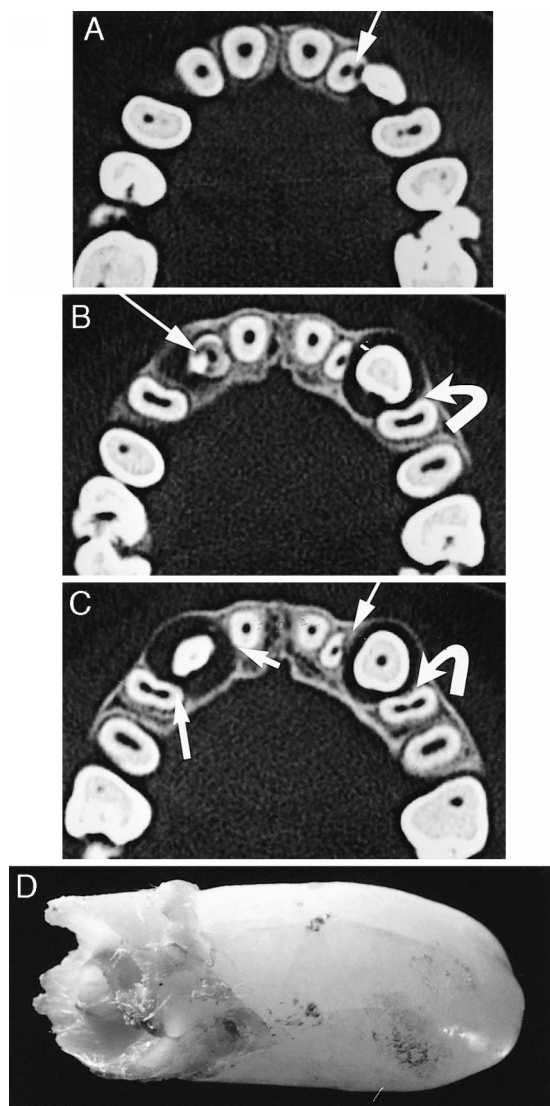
Findings in a 12-year-old boy. (A–C) Axial computed tomography (CT) scans obtained on the same occasion. No. 13 is erupting apically to No. 12. The dental follicle is symmetrically enlarged (C, arrows). The buccal cusp of No. 13 hits the root of No. 12 (B, arrow). There is extensive resorption of No. 12 close to the buccal cusp of No. 13. The periodontal contours of No. 14 and No. 11 have been resorbed near the dental follicle of No. 13 (C, arrows). No resorption of No. 14 and No. 11 can be seen. No. 23 is erupting distally to No. 22. The mesial corner of the buccal cusp of No. 23 is in contact with No. 22. Severe resorption of the root of No. 22 in the contact zone (A, arrow). In (C), the prominent part of the crown of No. 23 has passed. The resorbed area and the periodontal contour of No. 22 are being rebuilt (C, arrow). The dental follicle of No. 23 has exposed the root of No. 24 mesially (B, C curved arrows). There is no contact between the crown of No. 23 and the root of No. 24, and no resorption of No. 24 can be seen. (D) Extracted No. 12 showing extensive root resorption.
